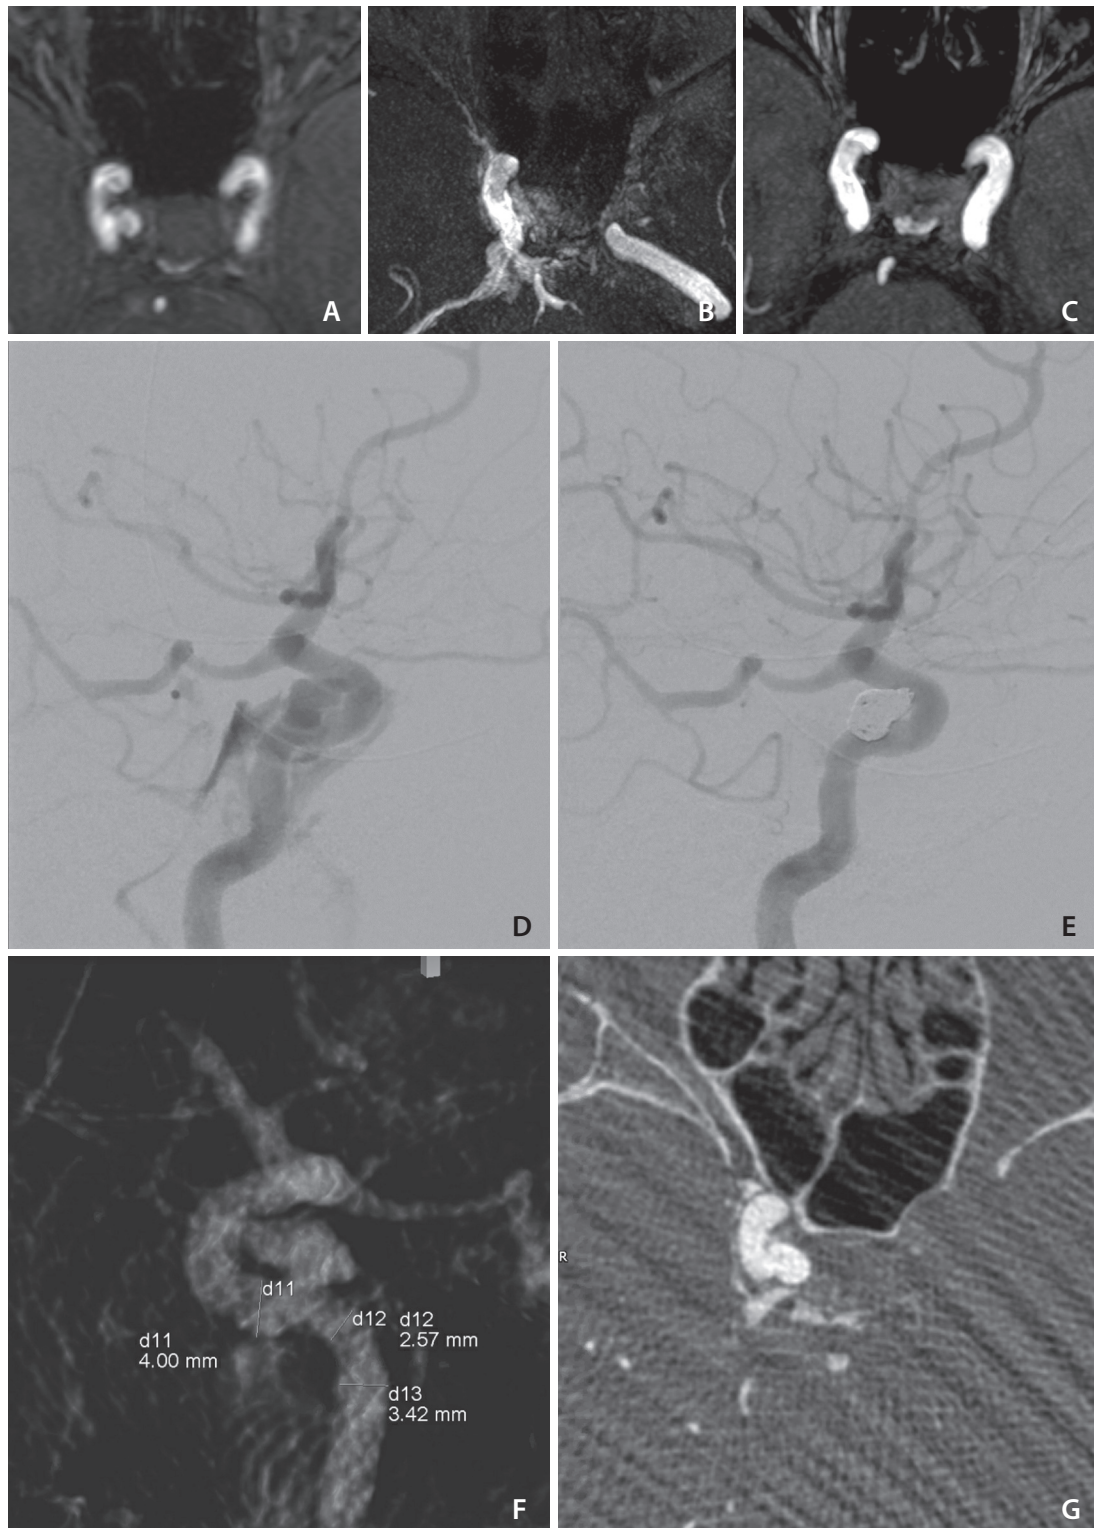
Magnetic resonance angiography (MRA) axial images showing previously unruptured right cavernous internal carotid artery aneurysm 6 years prior in time-of-flight sequence (A), evidence of rupture into the cavernous sinus in the present admission in time-resolved imaging of contrast kinetics sequence (B), and complete occlusion on control MRA in 6 months post embolization (C). Image quality of gadolinium enhanced digital subtraction angiography images in lateral projection on pre-procedural (D) and post-coiling injections (E). Image quality of gadolinium enhanced three-dimensional rotational (F) and axial reformatted (G) images in cone-beam computed tomography acquisition used for working projection curation and procedure planning.
